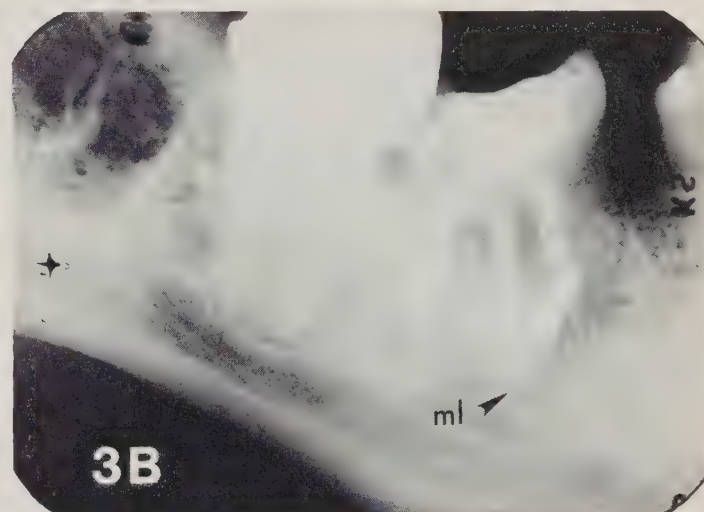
Pre-suture radiograph showing the inadequately resected mesiolingual apex. Note that the apical amalgam does not completely cover the lingual canal.
